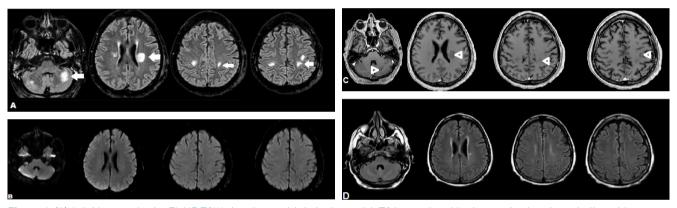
(A) Axial images in the FLAIR T2W showing multiple lesions with T2 hypersignal in the cerebral and cerebellar white matter (arrows), with no mass effect. (B) Axial diffusion (DWI) — Absence of restriction on diffusion in the topography of the lesions and (C) axial T1 post-contrast (Gd) show no enhancement (arrowhead). (D) Control examination after corticosteroid therapy showing marked involution of brain lesions and disappearance of cerebellar lesions in the axial FLAIR T2W images.
